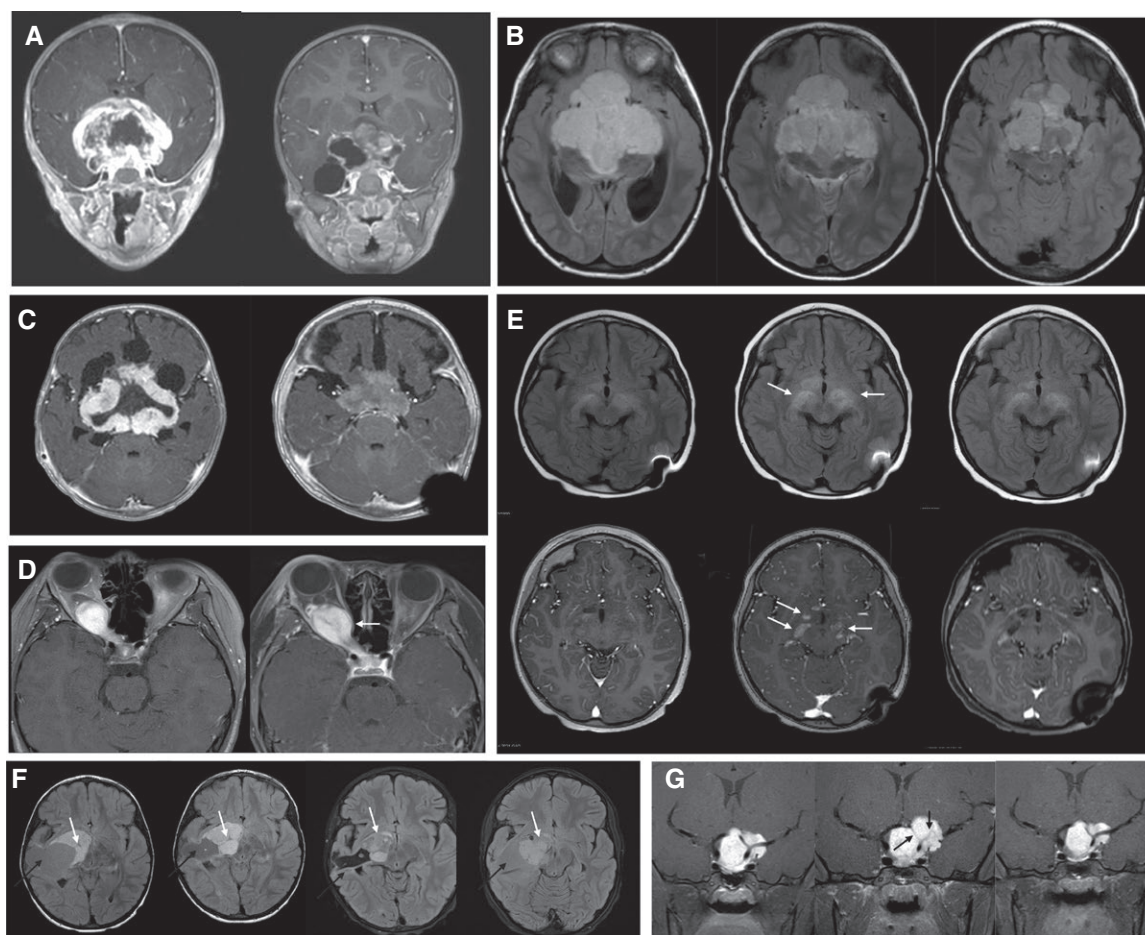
Varied response dynamics and trajectories following RAS/MAPK inhibition in pediatric low-grade gliomas. (A) Response to MEK-inhibitor within 3 months of treatment initiation in a patient with chemotherapy-refractory PLGG with a *KIAA1549-BRAF* fusion transcript. (B) A more typical slower response to MEK-inhibition in a chemotherapy refractory, BRAF-fused low-grade glioma, with slow and continued reduction of tumor dimensions at 6 and 12 months after start of treatment. (C) Relatively rapid radiological response within 2 months of initiation of dabrafenib monotherapy in a chemotherapy refractory, progressive, PLGG with *BRAF*p.V600E. (D) True, sustained progression (white arrow) of an isolated optic nerve glioma with BRAF-fusion following MEK-inhibitor treatment over consecutive scans, suggesting intrinsic resistance to this treatment. (E) A child with PLGG with *BRAF*p.V600E and initial response to dabrafenib and trametinib had to stop drugs due to toxicity, leading to rapid “rebound” growth (white arrows; T2/FLAIR sequences above and T1-contrast enhanced sequences below) and clinical deterioration within weeks of treatment interruption. Concomitant management of toxicity while reinitiating targeted therapy led to radiological response and clinical improvement. (F) A child with chemotherapy-refractory, progressive BRAF-fused PLGG with a solid (white arrow) and cystic (black arrow) component causing pressure effects, was managed with insertion of an Ommaya reservoir for the cyst decompression, and initiated on MEK-inhibitor. Response was demonstrated over time, in terms of reduction of both the solid and cystic components, and treatment was stopped after prolonged disease stability was observed on serial imaging (image 3). However both components demonstrated slow and sustained regrowth over the next year (image 4) as the patient remained off-treatment, suggesting need for re-treatment. (G) Initial increase in dimensions of a BRAF-fused PLGG on a pan-RAF inhibitor, as seen by the increase in size and obliteration of intervening blood vessels (black arrows), which started to respond after continuation of the same treatment over the next couple of months, akin to a pseudo-progression like phenomenon.
